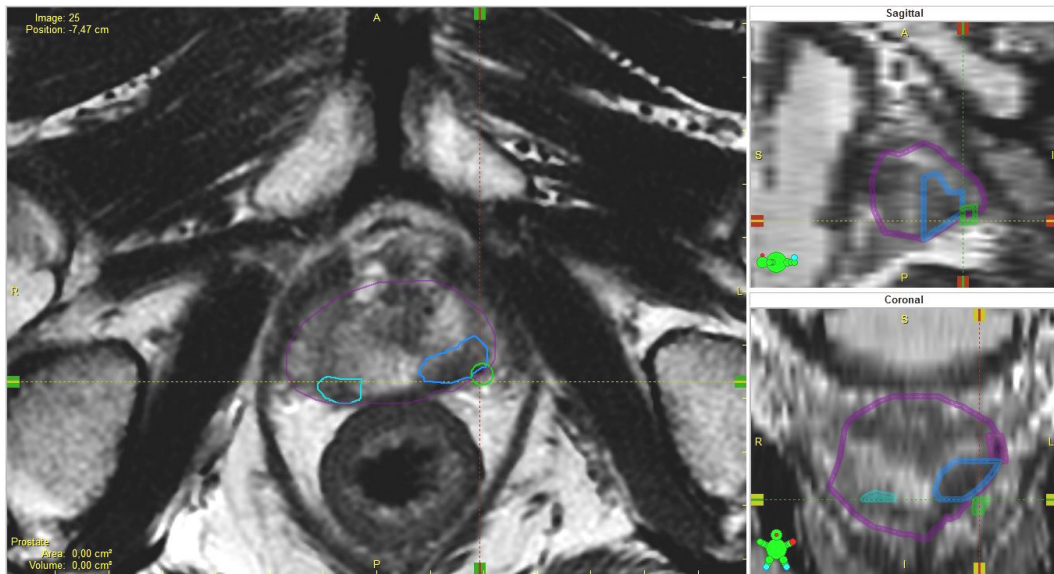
Contoured MRI study of patient 7 in VariSeed. Prostate_{MRI} (magenta), Boost₁ (light blue) and Boost₂ (turquoise) contoured on T2 and a FM (green) localized on T1. Image blending is set to T2.
